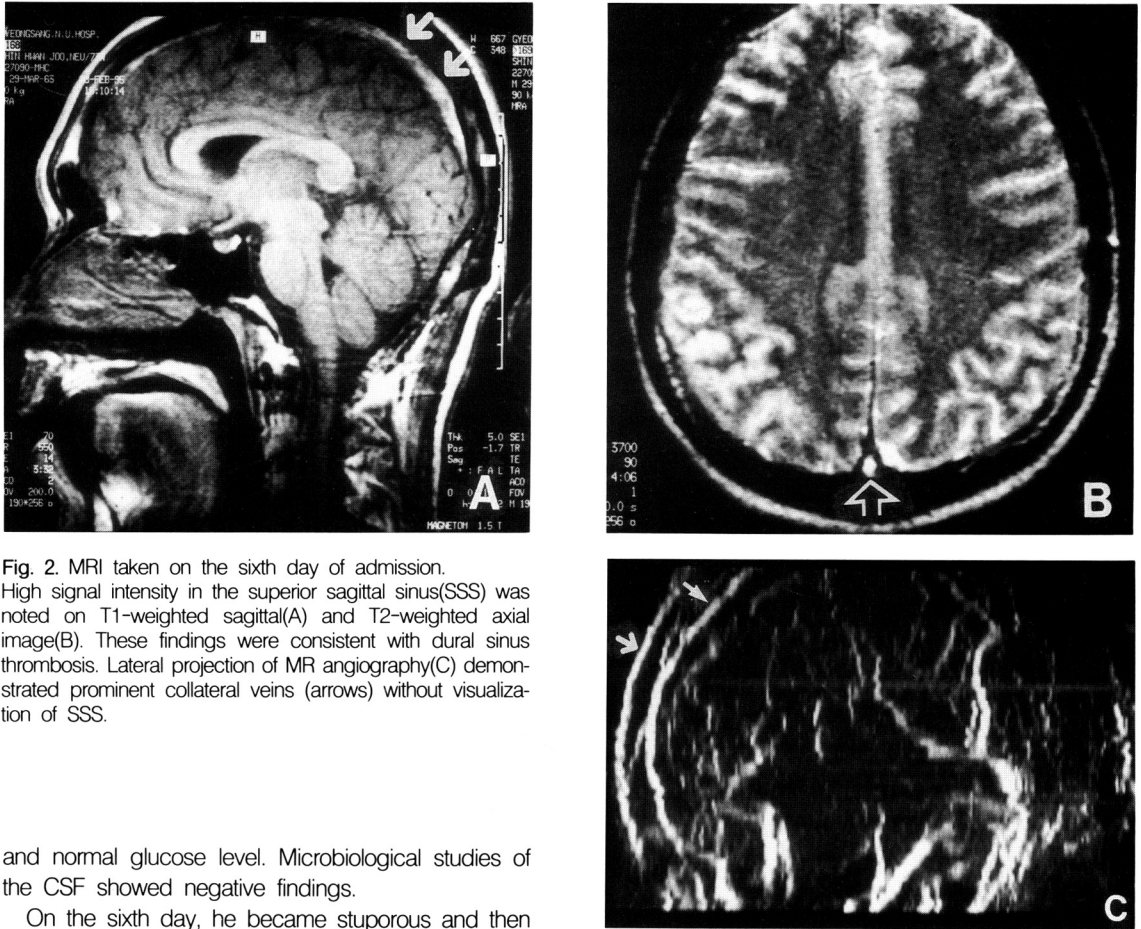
MRI taken on the sixth day of admission. High signal intensity in the superior sagittal sinus(SSS) was noted on T1-weighted sagittal(A) and T2-weighted axial image(B). These findings were consistent with dural sinus thrombosis. Lateral projection of MR angiography(C) demonstrated prominent collateral veins (arrows) without visualization of SSS.
